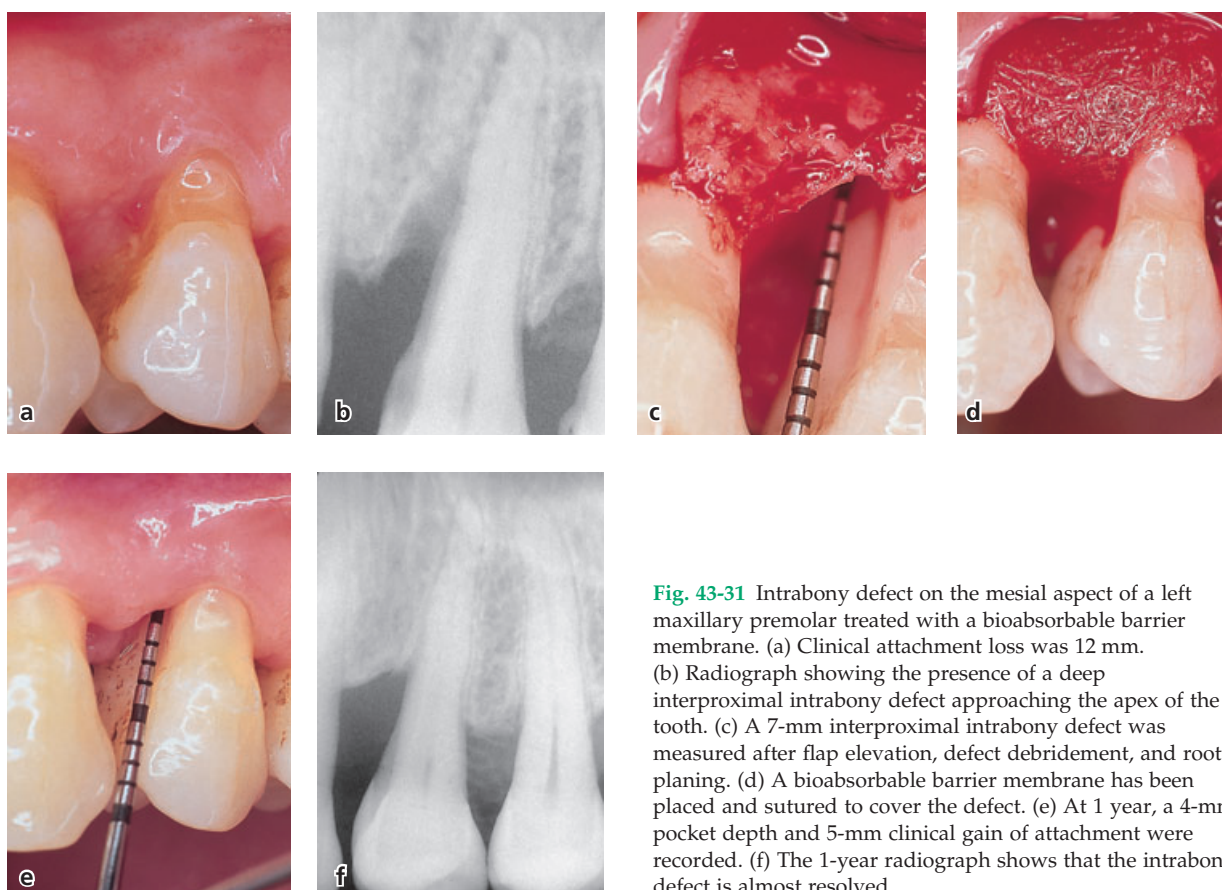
Intrabony defect on the mesial aspect of a left maxillary premolar treated with a bioabsorbable barrier membrane. (a) Clinical attachment loss was 12 mm. (b) Radiograph showing the presence of a deep interproximal intrabony defect approaching the apex of the tooth. (c) A 7-mm interproximal intrabony defect was measured after flap elevation, defect debridement, and root planing. (d) A bioabsorbable barrier membrane has been placed and sutured to cover the defect. (e) At 1 year, a 4-mm pocket depth and 5-mm clinical gain of attachment were recorded. (f) The 1-year radiograph shows that the intrabony defect is almost resolved.
